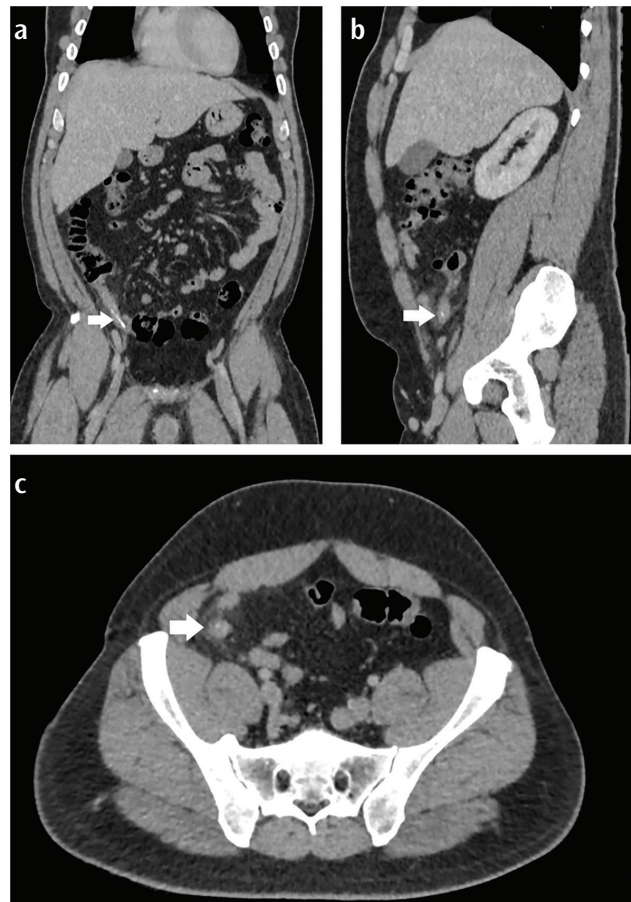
Coronal (a), sagittal (b), and axial (c) computed tomography planes demonstrating a foreign body in the cecal appendix (white arrow).
